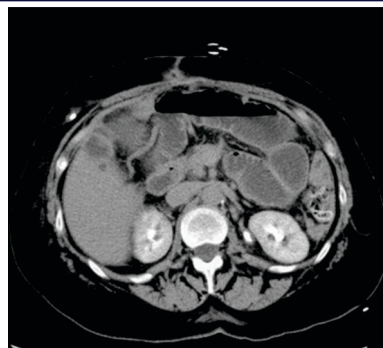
CT axial section showing dilated duodenum to the left of midline
